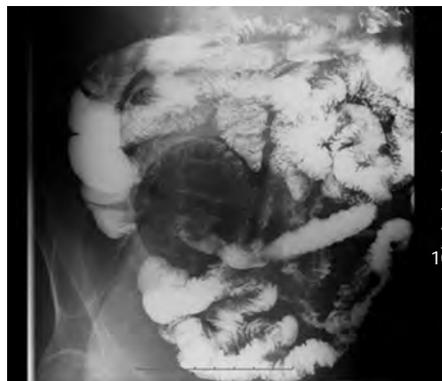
Radiography of the whole digestive tract showed that the terminal ileal mucosa was thickened and peristalsis was poor.
